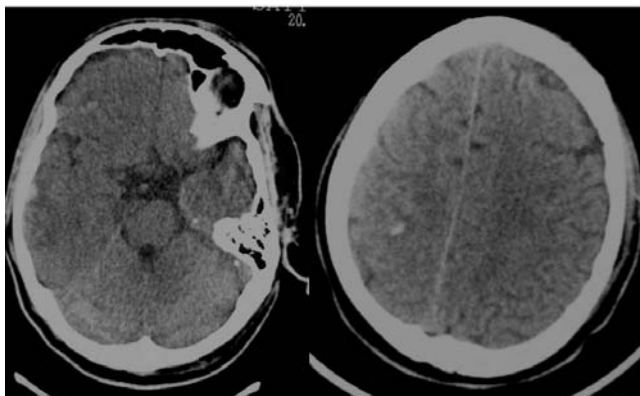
CT scan performed after the episode of seizures showing multiple contusions in right frontal, temporal and parietal lobe.
